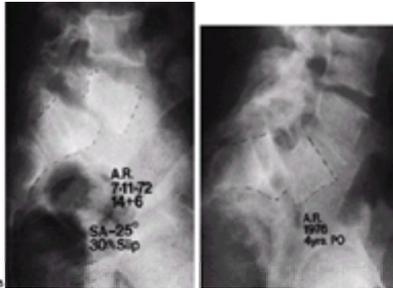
A patient was seen at the age of 14 years 6 months with chronic low back pain. A: The lateral lumbar view showed spondylolisthesis with a 30% slip and a -25-degree slip angle. An L4-to-sacrum fusion was performed, followed by postoperative immobilization in a cast. B: Four years after operation, a radiograph shows a solid fusion with no alteration in displacement or slip: a fusion *in situ*. The patient had complete pain relief.
